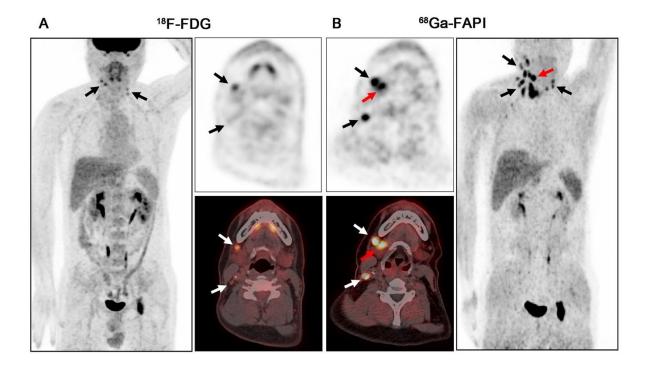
PET/CT scans with the <sup>18</sup>F-FDG (A) and <sup>68</sup>Ga-FAPI (B) in a 41-year-old male patient (patient 5) with metastatic adenocarcinoma of the right neck. <sup>18</sup>F-FDG-PET/CT was negative for the detection of the primary. On <sup>68</sup>Ga-FAPI-PET/CT, there was an intensive uptake in the right submandibular gland (B, red arrow; SUV<sub>max</sub> = 15.80), while low background uptake was seen in the left submandibular gland (SUV<sub>max</sub> ratio = 6.87). Subsequent surgery confirmed salivary ductal carcinoma. Black and white arrows indicate the metastatic lymph nodes.
